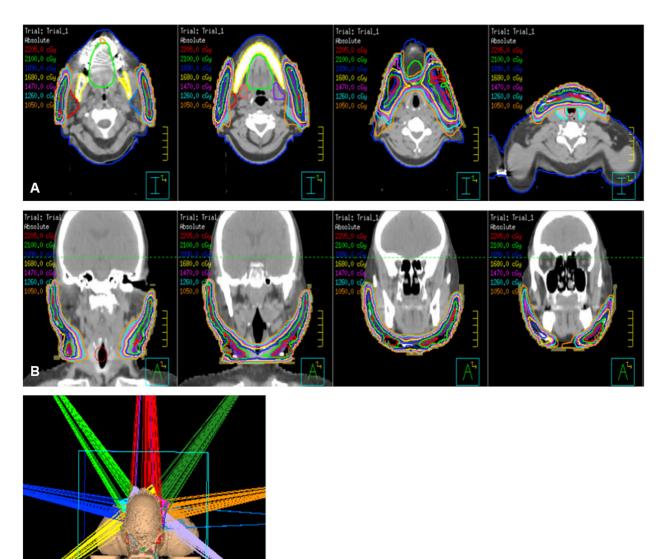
A 56-year-old woman with a history of recurrent keloid of the anterior aspect of the neck and both keloids of the jawline. Axial (A) and coronal (B) computed tomography images representing an intensity-modulated radiotherapy treatment plan using step-and-shoot to deliver 21 Gray in 3 fractions to the bilateral aspects of the head and neck. A 1-cm bolus was used over the entire treatment area. Excellent sparing of organs at risk is demonstrated, including the salivary glands, mandible, thyroid, oral cavity, and larynx. C, Three-dimensional rendition of the step-and-shoot fields delivered.
